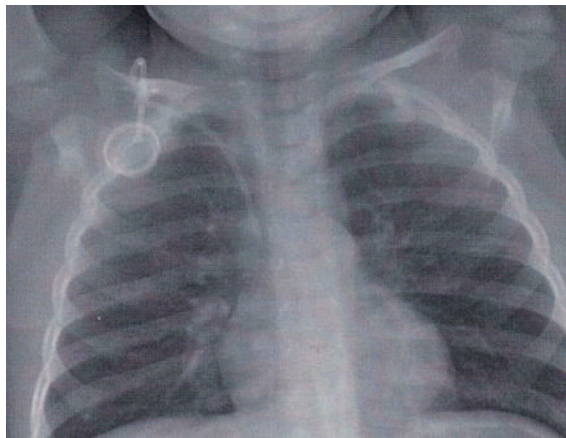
Chest X-ray immediately after implantation of the Port-a-Cath system showing the correct position of the system with the distal end of the canula in the superior vena cava.
